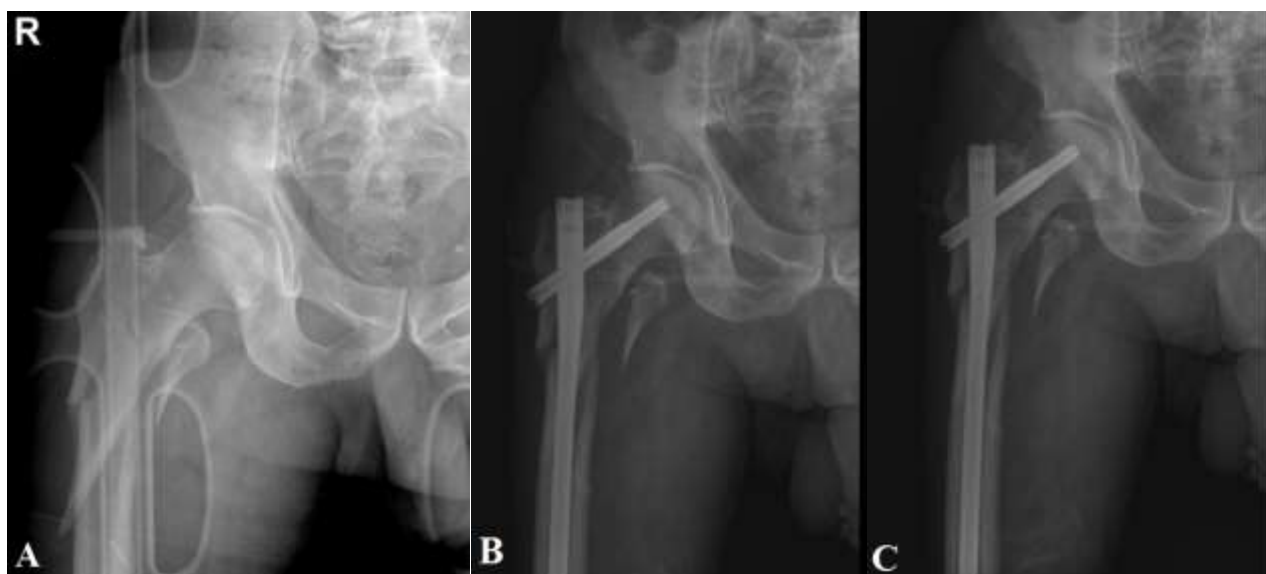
(A)- Simple subtrochanteric fracture, AP view; (B)- postoperative radiograph showing osteosynthesis with laterally curved nail - AP view; (C) – 1 month's postoperative radiograph showing maintained reduction in osteosynthesis with laterally curved – AP view
